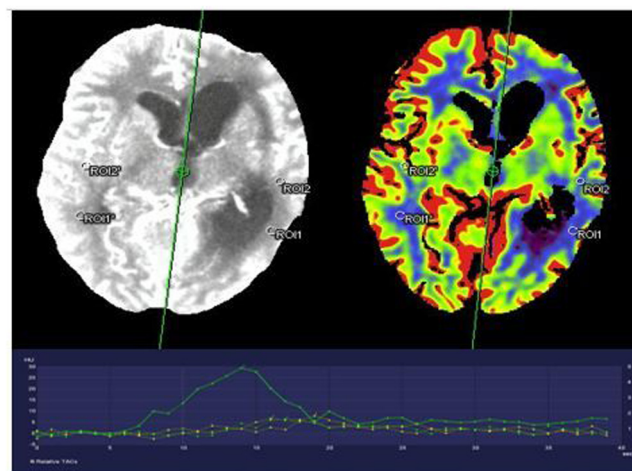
CT-Perfusion scan-Region of Interest (ROI) in the territory of MCA selected and CBF, CBV and TTP Parameters were obtained from the graph in case 8.
